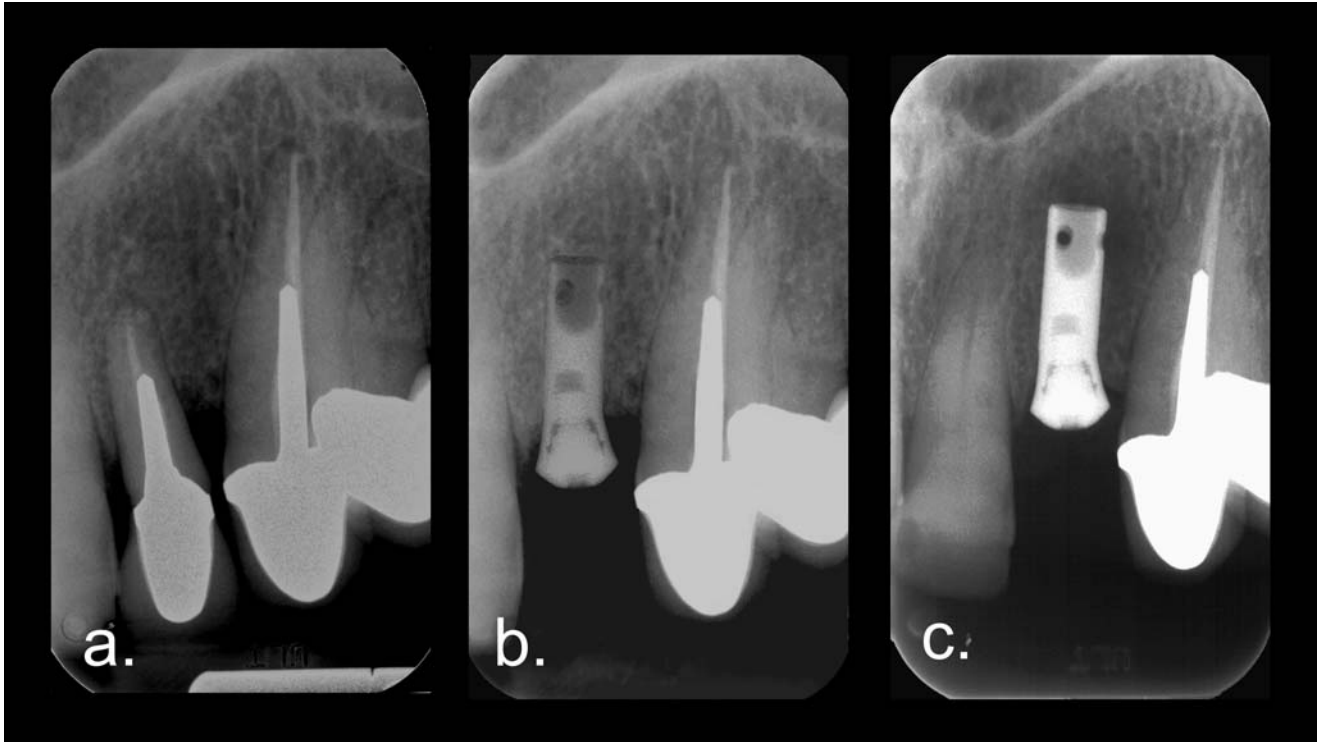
Patient GL, a 78-year-old woman. (a) Nine years after placement of a postanchored restoration, the upper-left lateral incisor developed pain on pressure, indicating a fissure of the root. (b) Five months after the tooth's extraction, a hollow-screw implant was placed, which allowed healing without complications. (c) After 6 months, a bluish coloration of the gingiva was noted and a radiograph revealed a lateral and periapical radiolucency. The implant was painless and clinically functional; hence, the implant was fitted with a provisional crown. However, 2 months after being informed of her situation, the patient elected not to pursue treatment at our office and was lost to follow-up.
